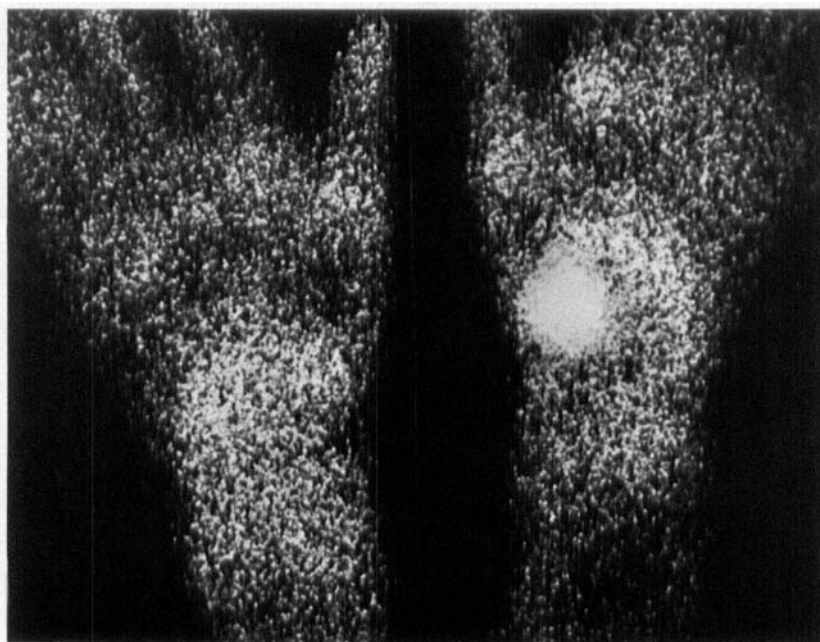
Left: normal tracer uptake in the wrist region. Right: focal increased accumulation radially in the wrist. Radiography revealed fracture in the scaphoid bone.
